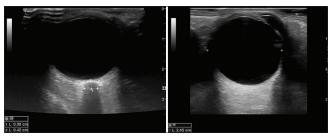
Ultrasound measurement of ONSD and ETD. ETD = eyeball transverse diameter, ONSD = optic nerve sheath diameter
